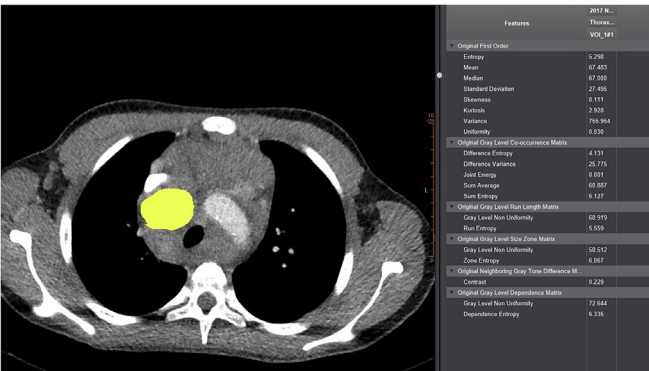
Axial CT image; in a patient with HL, the pre-treatment tissue analysis program monitors the results of tissue analysis of the ROI area (yellow area) and statistical parameters drawn for lymphadenopathies in the mediastinum
